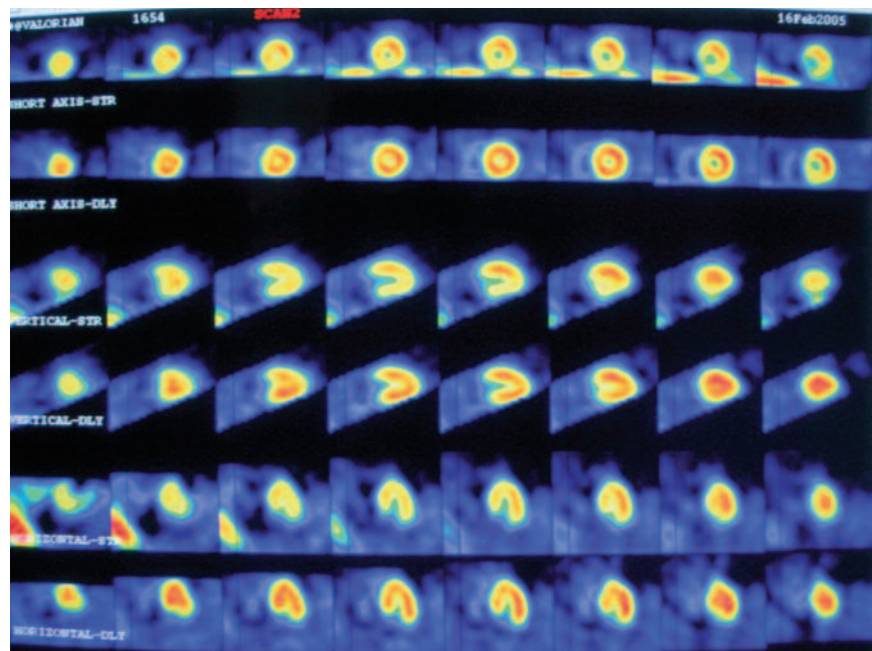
The initial set images of the patient showed irreversible defects in the apex, anteroapical, inferoapical, anteroseptal, septal and also anterior walls. The upper rows indicate 30 minute rest 99mTc-sestamibi SPECT images and lower rows 180 minutes rest 99mTc-sestamibi SPECT images.
